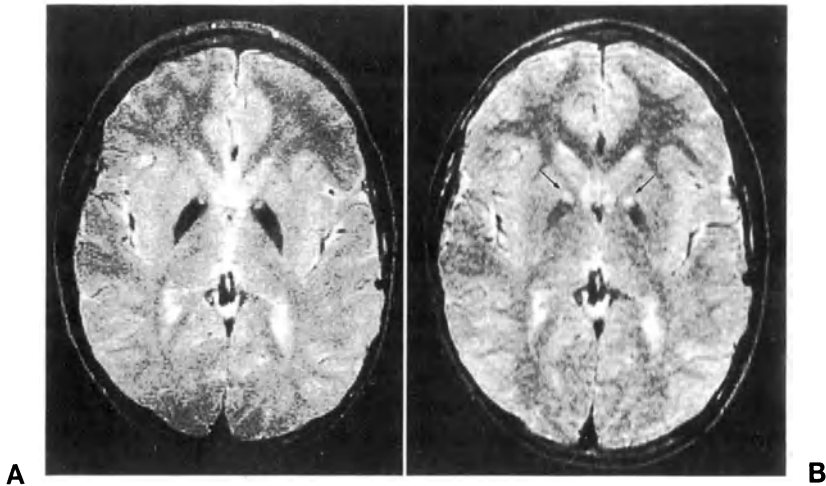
Hallervorden-Spatz disease. T2-weighted images obtained at different field intensities (A 1.5 T; B 0.5 T) demonstrate the dependence of the magnetic susceptibility effects due to iron in the pallidum on the field strength; the loss of signal intensity caused by iron is much more evident at 1.5 T (A). The area of high signal intensity in the anteromedial part of the pallidum (eye-of-the-tiger sign) is more evident at 0.5 T (arrows, B). [From AJNR (Savoirdo et al., 1993), with permission]
